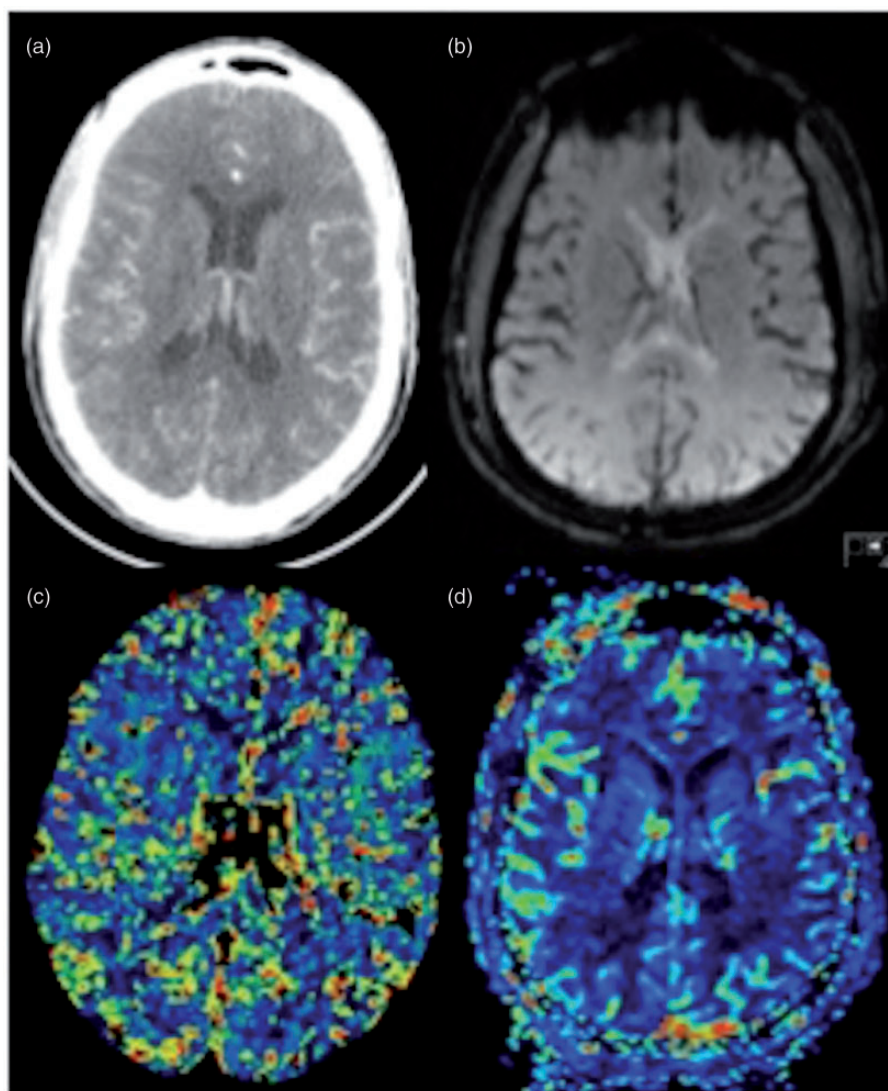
Source images of perfusion studies on CT (a) and MR (b). After postprocessing, color maps of the several parameters can be obtained. CBF maps on CT (c) and MR (d) of the same patient show relatively symmetric perfusion of both hemispheres.
